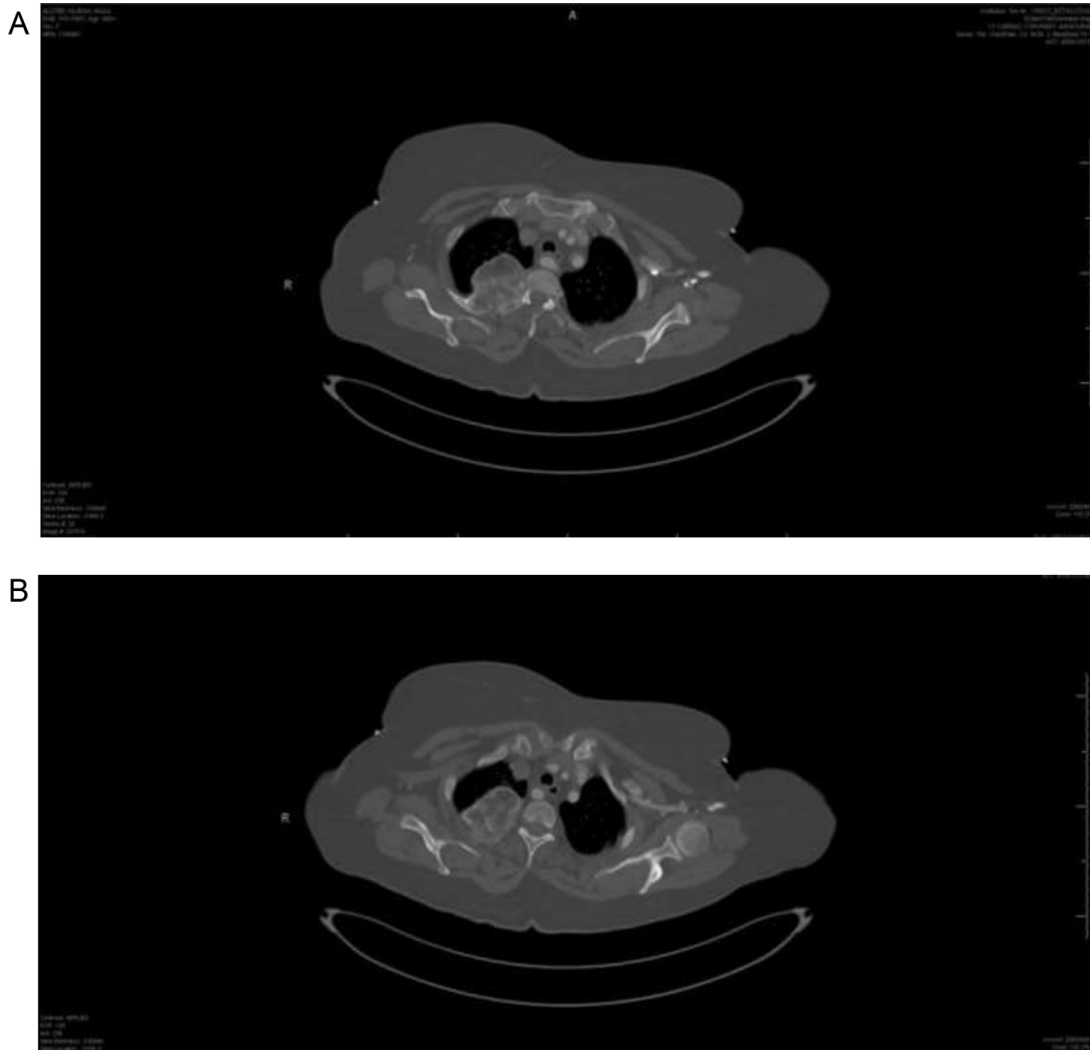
Contrast-enhanced CT scan demonstrating a large expansile lytic lesion of the right third rib with no cortical destruction. No adjacent soft-tissue and lung parenchymal involvement is seen.
